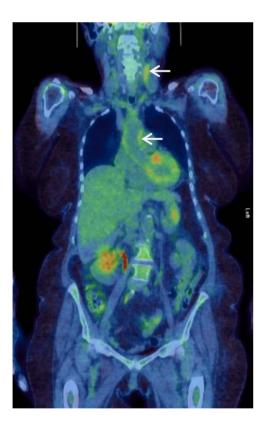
Coronal fused positron emission tomography demonstrating increased left carotid (SUVmax 4.6) and ascending aortic fluorodeoxyglucose uptake.
